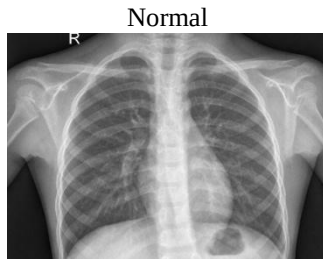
Chest X-ray Normal
